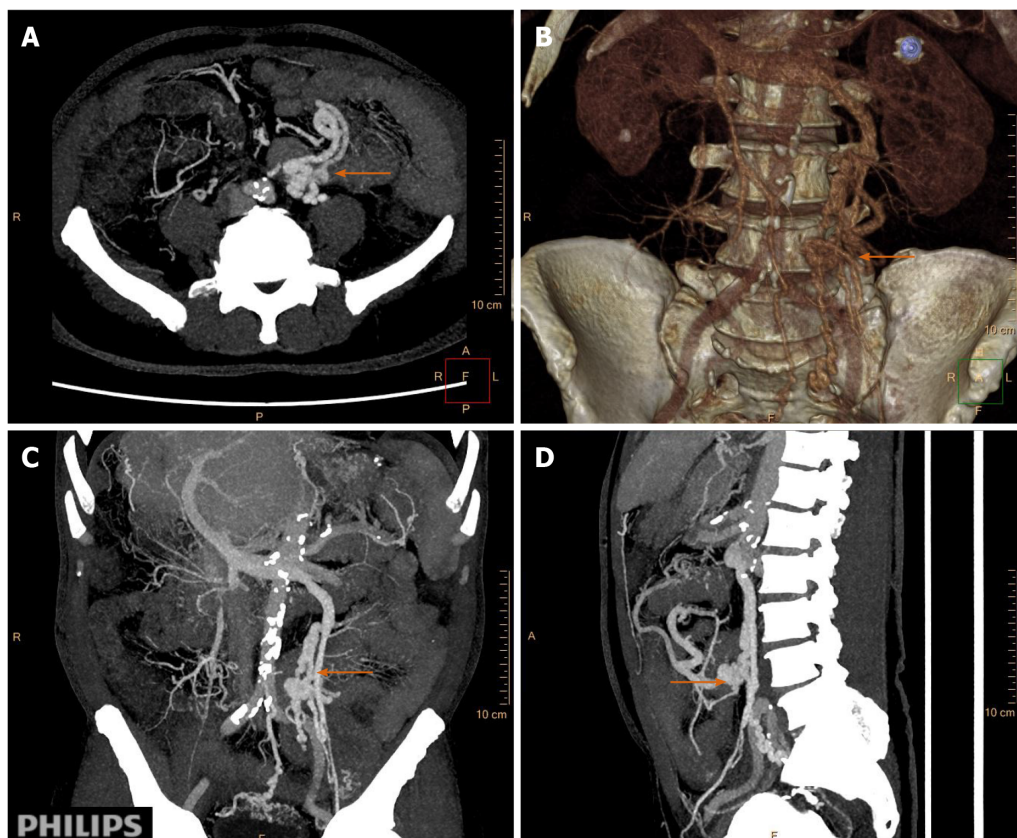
Multiplanar reconstruction showed a varicocele on the left side and venae testicularis as a tangled mass of vessels forming varicose veins, which anastomosed with the superior mesenteric vein (orange arrow). A: Axial plus coronal scanning; B: Sagittal scans; C: Images reconstructed with maximum intensity projection; and D: Images showing volume rendering three-dimensional reconstruction by spiral computed tomography.
